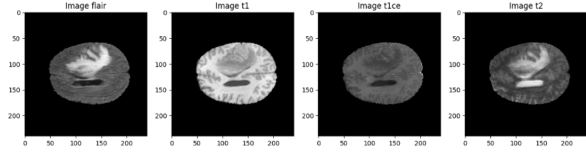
Four common modalities of a brain MRI (ordered accordingly): FLAIR (emphasizes tumors), T1 (focuses on overall structure), T1w (emphasizes anatomical detail with fat appearing bright and water dark), T2 (emphasizes water content and tumor).
